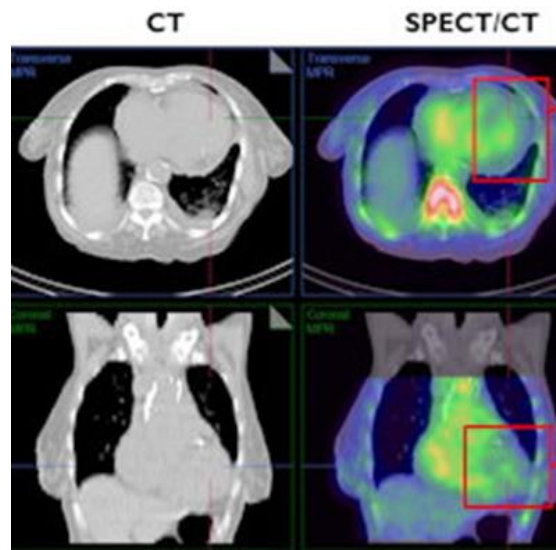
SPECT/CT fusion imaging(Hybrid Imaging) offers significant advantages over SPECT alone for imaging cardiac amyloidosis by reducing false positives
